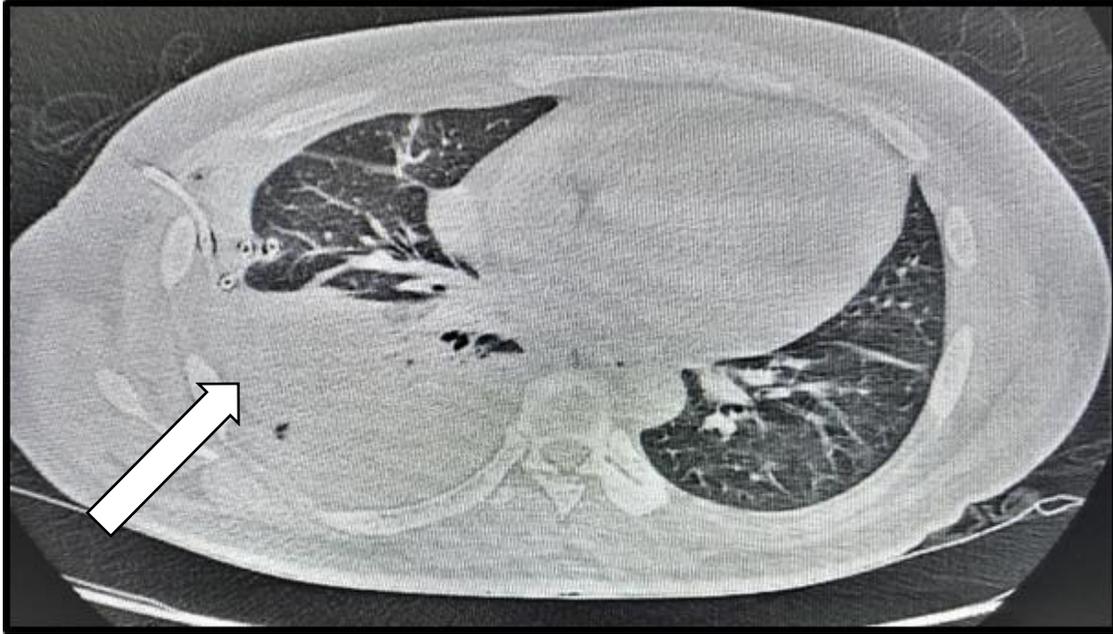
CT-chest after insertion of a pigtail catheter.
